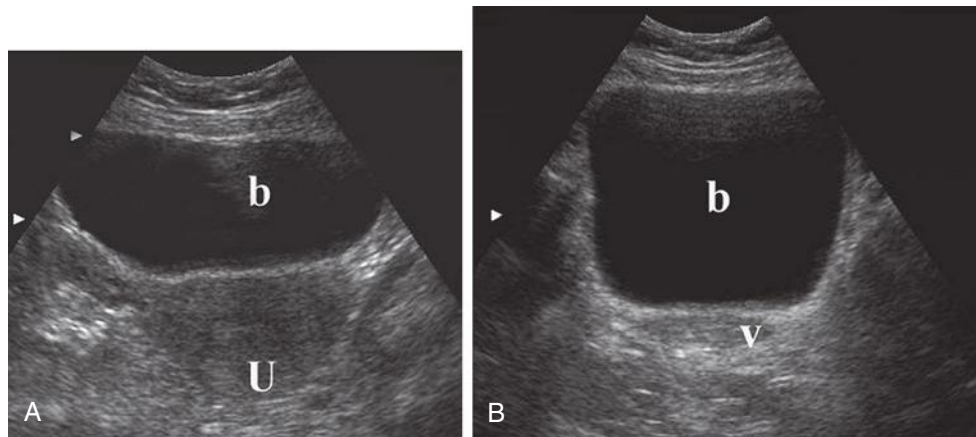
Normal urinary bladder. A, Transverse transabdominal sonogram of the urinary bladder at the level of the corpus of the uterus (U). At this level, the bladder (b) has a rounded or oval configuration. B, Transverse transabdominal sonogram of the urinary bladder at the level of the vagina (v). At this level, the bladder (b) has a square configuration. The normal bladder wall is thin, echogenic, and regular, measuring less than 3 mm in thickness.
